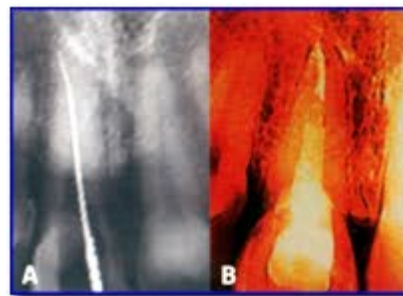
Magnified radiograph demonstrates instrumentation of the existing root canal space.
